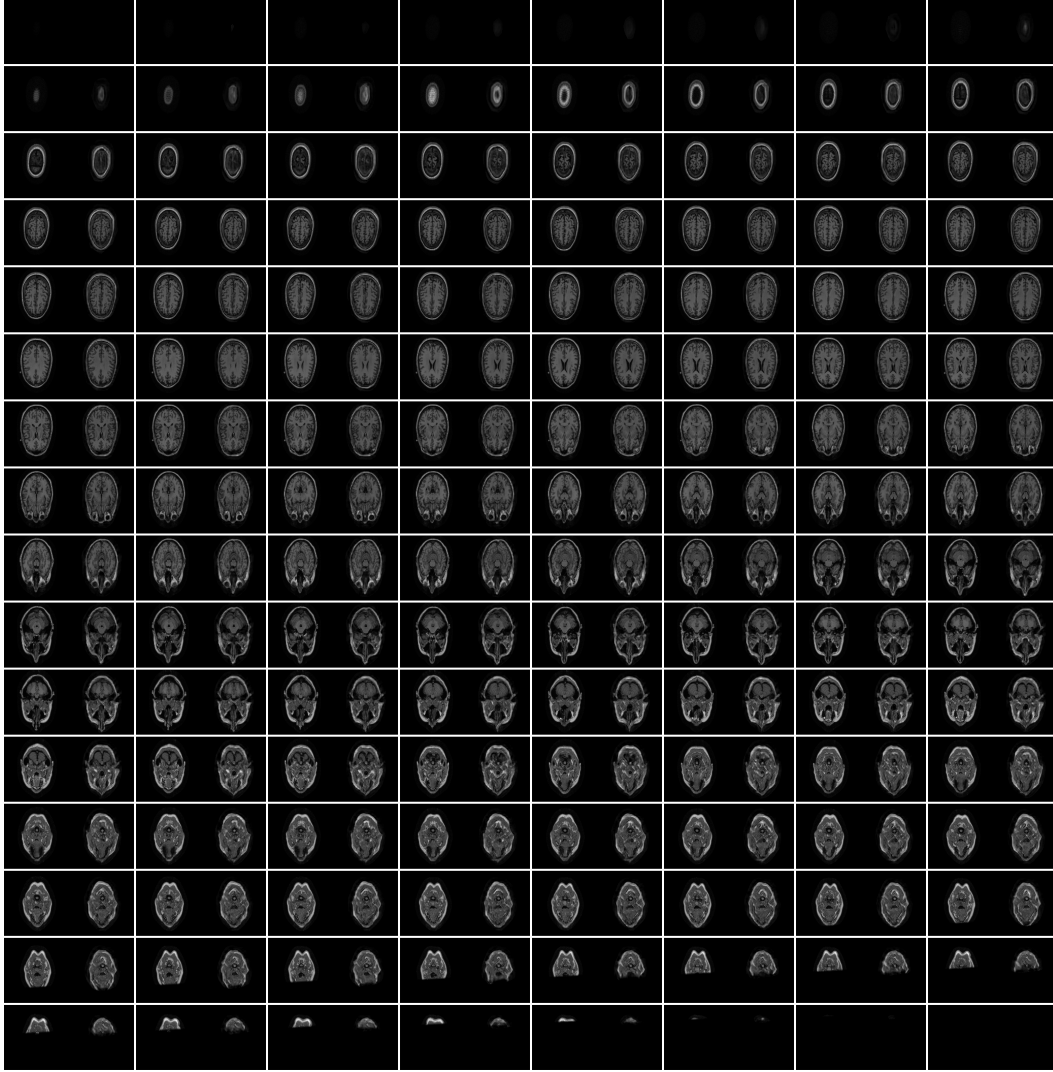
Original MRI slices and those generated from C-DeID-GAN (OASIS-3): Slices (of a single patient) run from left to right and from top to bottom. Each box corresponds to one slice index and contains the original on the left and the synthesized counterpart on the right.*
